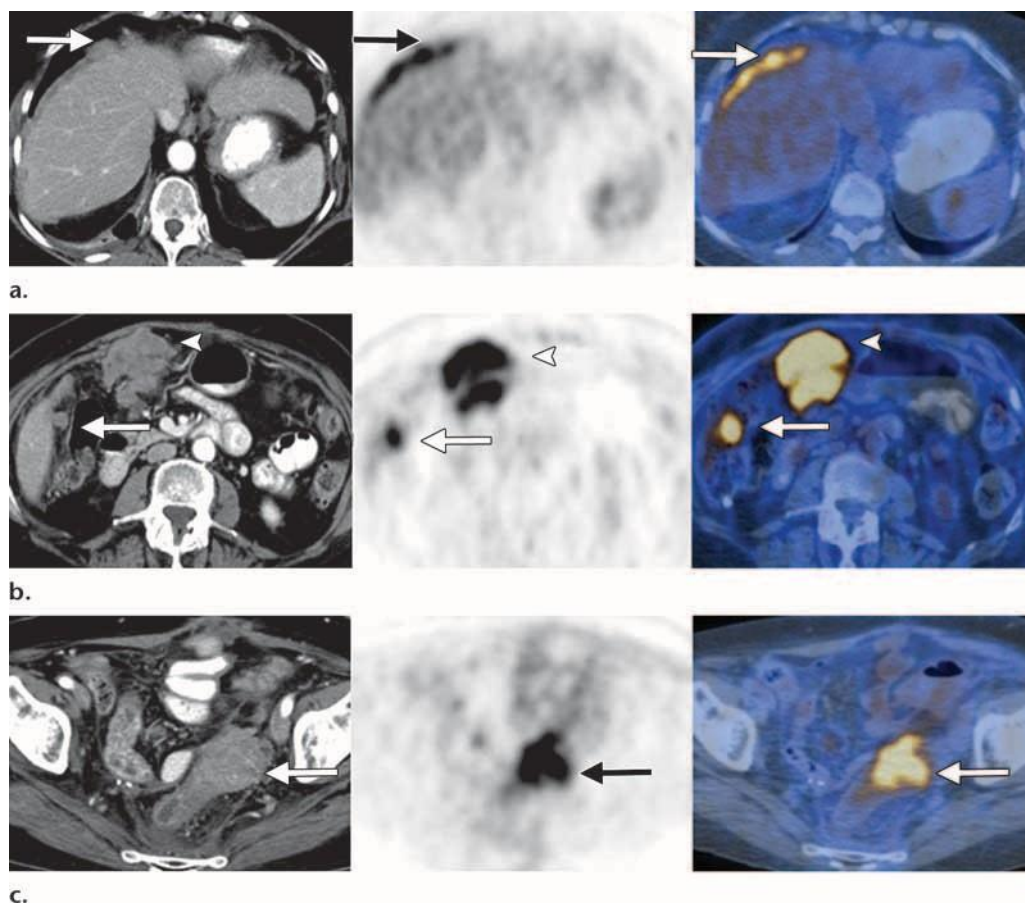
Peritoneal involvement in a 73-year-old woman with elevated CA-125 levels and a history of surgery and chemotherapy for stage IIIC ovarian serous papillary adenocarcinoma. (a) Axial contrast-enhanced CT (left), FDG PET (middle), and fused PET/CT (right) images obtained for restaging show irregular soft-tissue infiltration (arrow) in the subphrenic space along the liver convexity with markedly increased FDG uptake, a finding indicative of peritoneal tumor implants. (b) Axial contrast-enhanced CT (left), FDG PET
